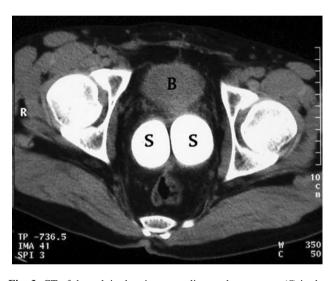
CT of the pelvis showing two adjacent dense stones (S) in the seminal vesicles just behind the urinary bladder (B)
